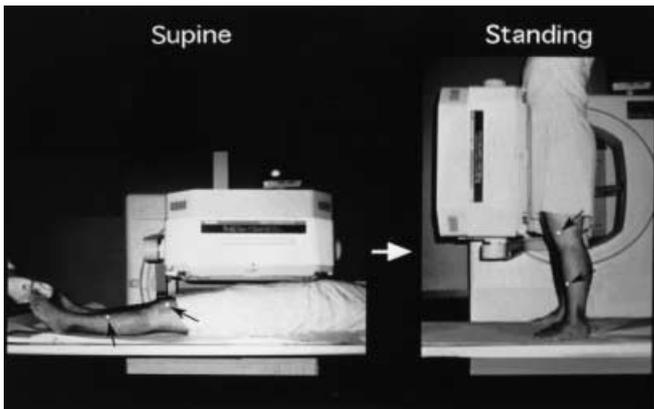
Dynamic lymphoscintigraphic test using a standing load. After intradermal injection of tracer into an interdigital space in each foot in the supine position, dynamic images covering both upper thighs and pelvis are recorded for 15 min. Then, the subject stands up slowly, and the gamma camera is reset using external markers (arrows) to replicate its position during data recording in the supine position. Dynamic images are again recorded for 15 min. During image acquisition, the subjects are instructed not to move their legs
